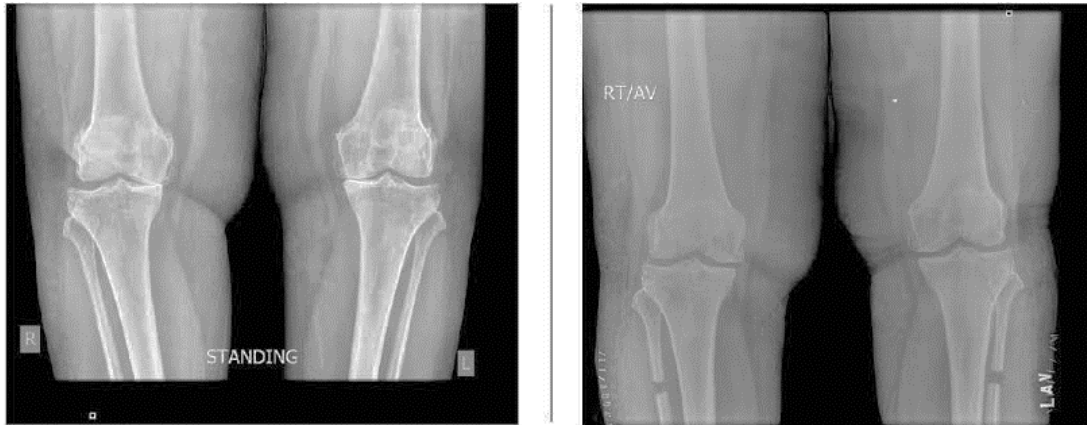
Preoperative and postoperative radiographs following PFO (Proximal Fibular Osteotomy) in the study subject
